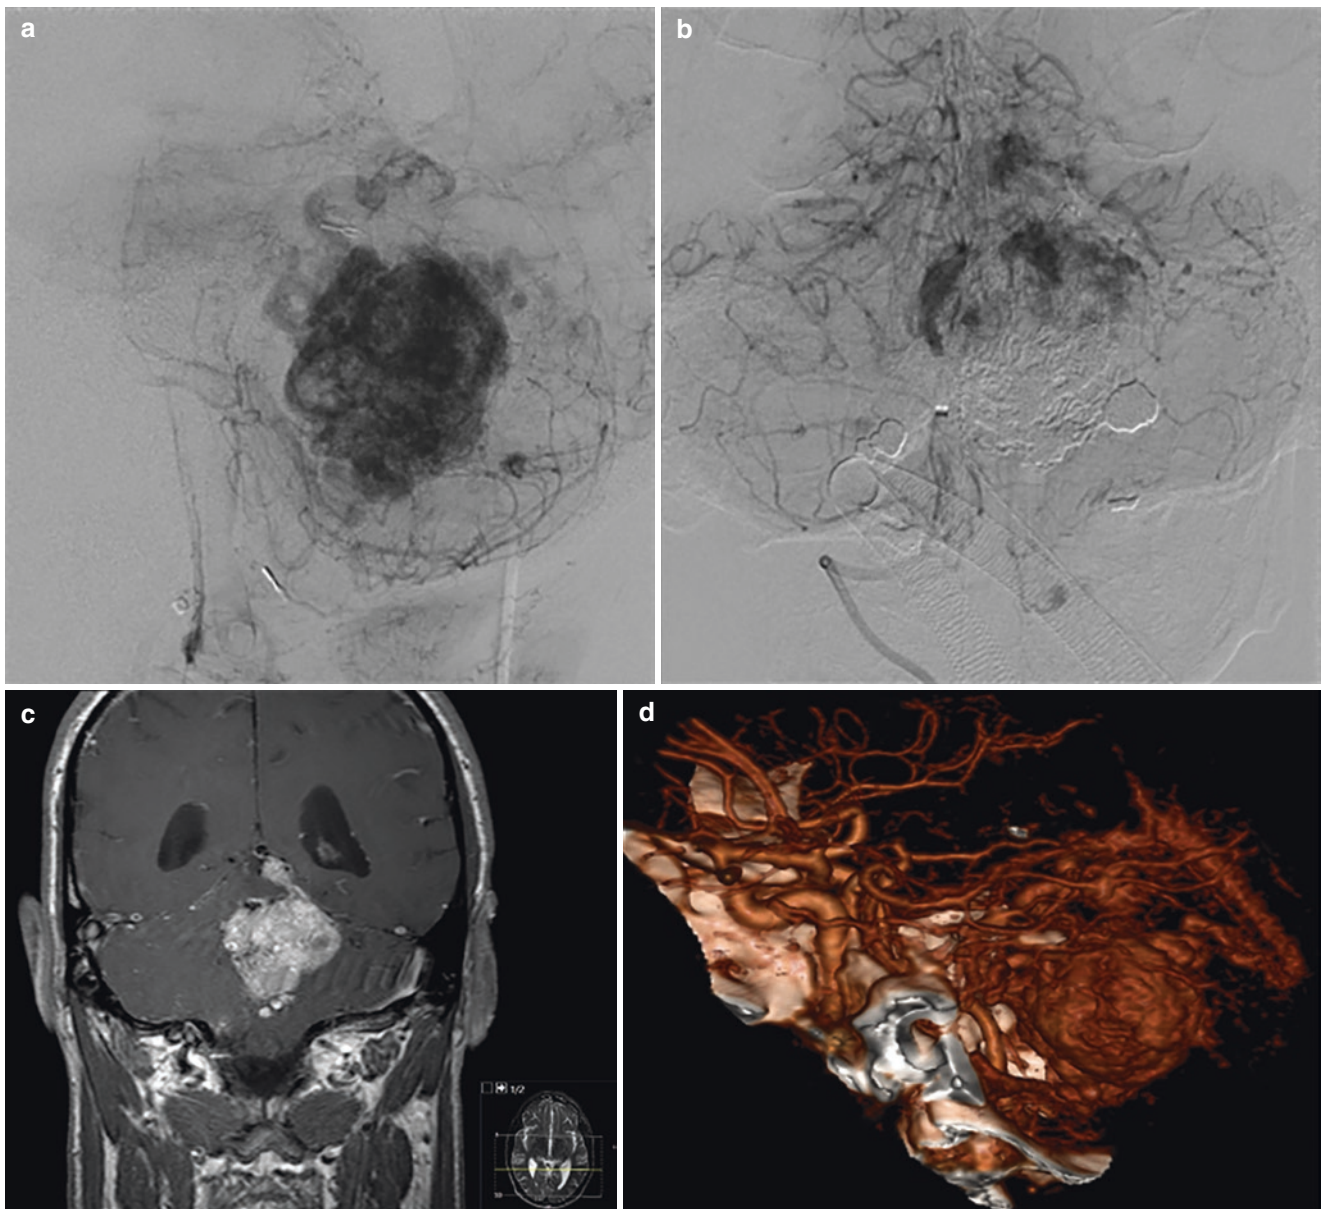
A large, complex haemangioblastoma. (a and b) Angiogram shows partial embolisation; (c) Coronal T1 with gadolinium; (d) pre-operative 3D reconstruction with CTA. Patient was treated with a combination of modalities: partial embolisation, followed by surgery and SRS
